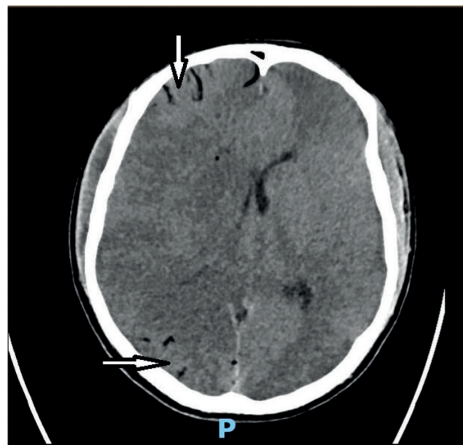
Computed tomography scan of the brain showing pneumocephalus (arrows) and cerebral oedema.
